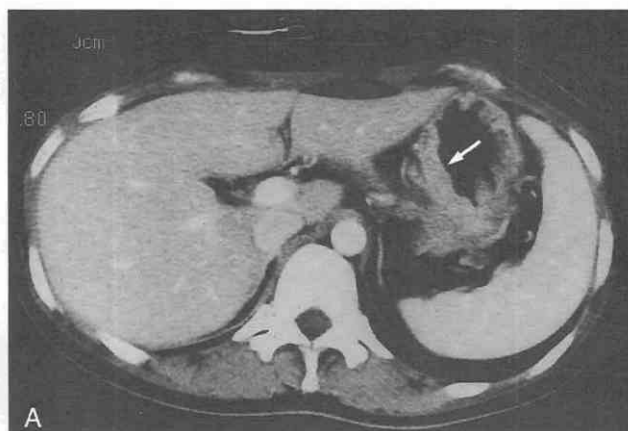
Gastric adenocarcinoma. Early phase (A) of a dynamic CT scan shows mild enhancement of thickened gastric wall (arrow). Scan shows good enhancement in the equilibrium phase (B).
